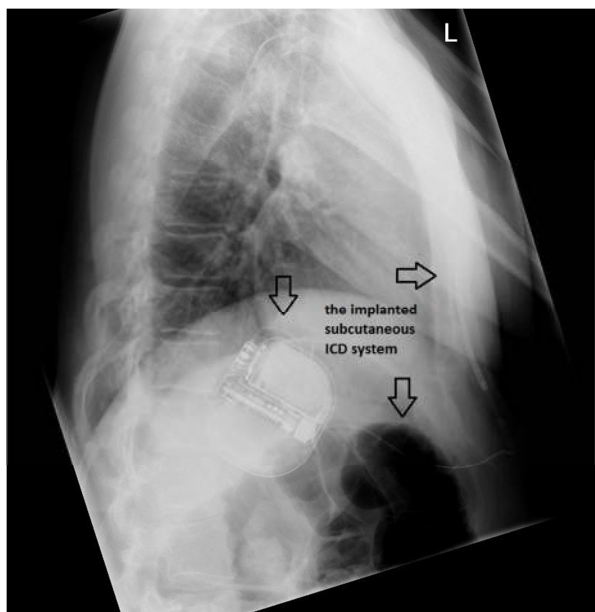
Chest radiograph (lateral view) showing the implanted subcutaneous ICD
